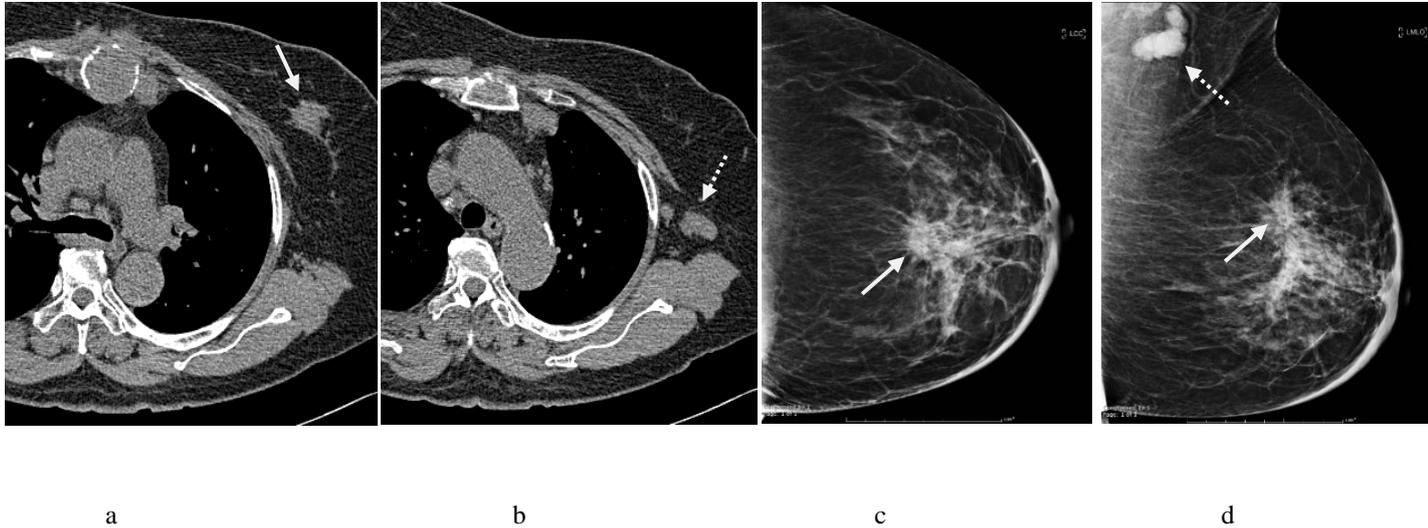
(a) Axial non-enhanced CT showed left breast mass with spiculated margin (arrow).
